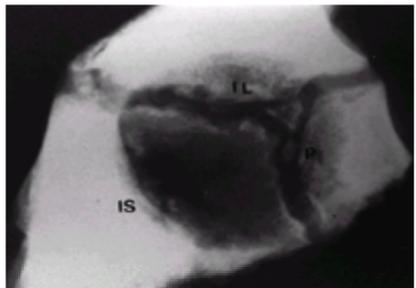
Lateral roentgenogram of the acetabulum of a 9-year-old girl. Two centers of ossification are seen within the cartilage adjoining the pubis (*P*) and appear to be developing within the vertical phalange of the triradiate cartilage. The positions of the ischium (*IS*) and the ilium (*IL*) are indicated. (From ref. [11](#), with permission.)
